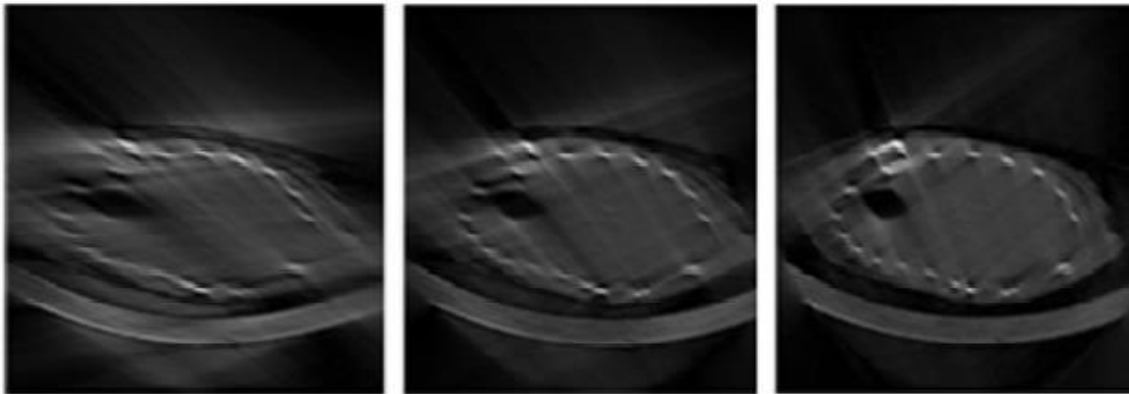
Artifacts derived from FDK(cone beam back-projection algorithm) with  $60^\circ$  (left),  $90^\circ$  (center) and  $130^\circ$  span angles.
